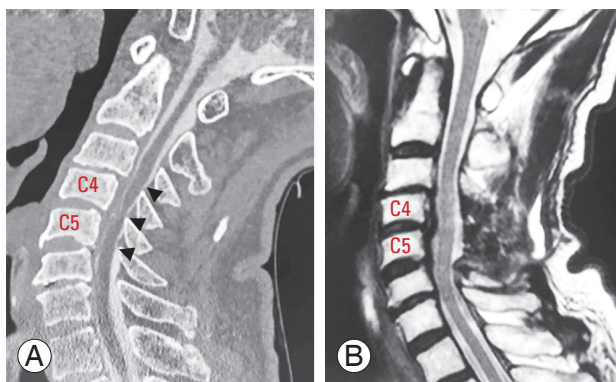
(A, B) Preoperative myelogram-computed tomography (CT) in extended position and postoperative magnetic resonance imaging (MRI) in a neutral position of a case with two consecutive laminectomies. The left CT sagittal section shows three intervertebral stenoses (arrowhead) between C3/4 and C5/6. The postoperative MRI on the right shows the decompression of the three intervertebral spaces by C4–5 laminectomy.
